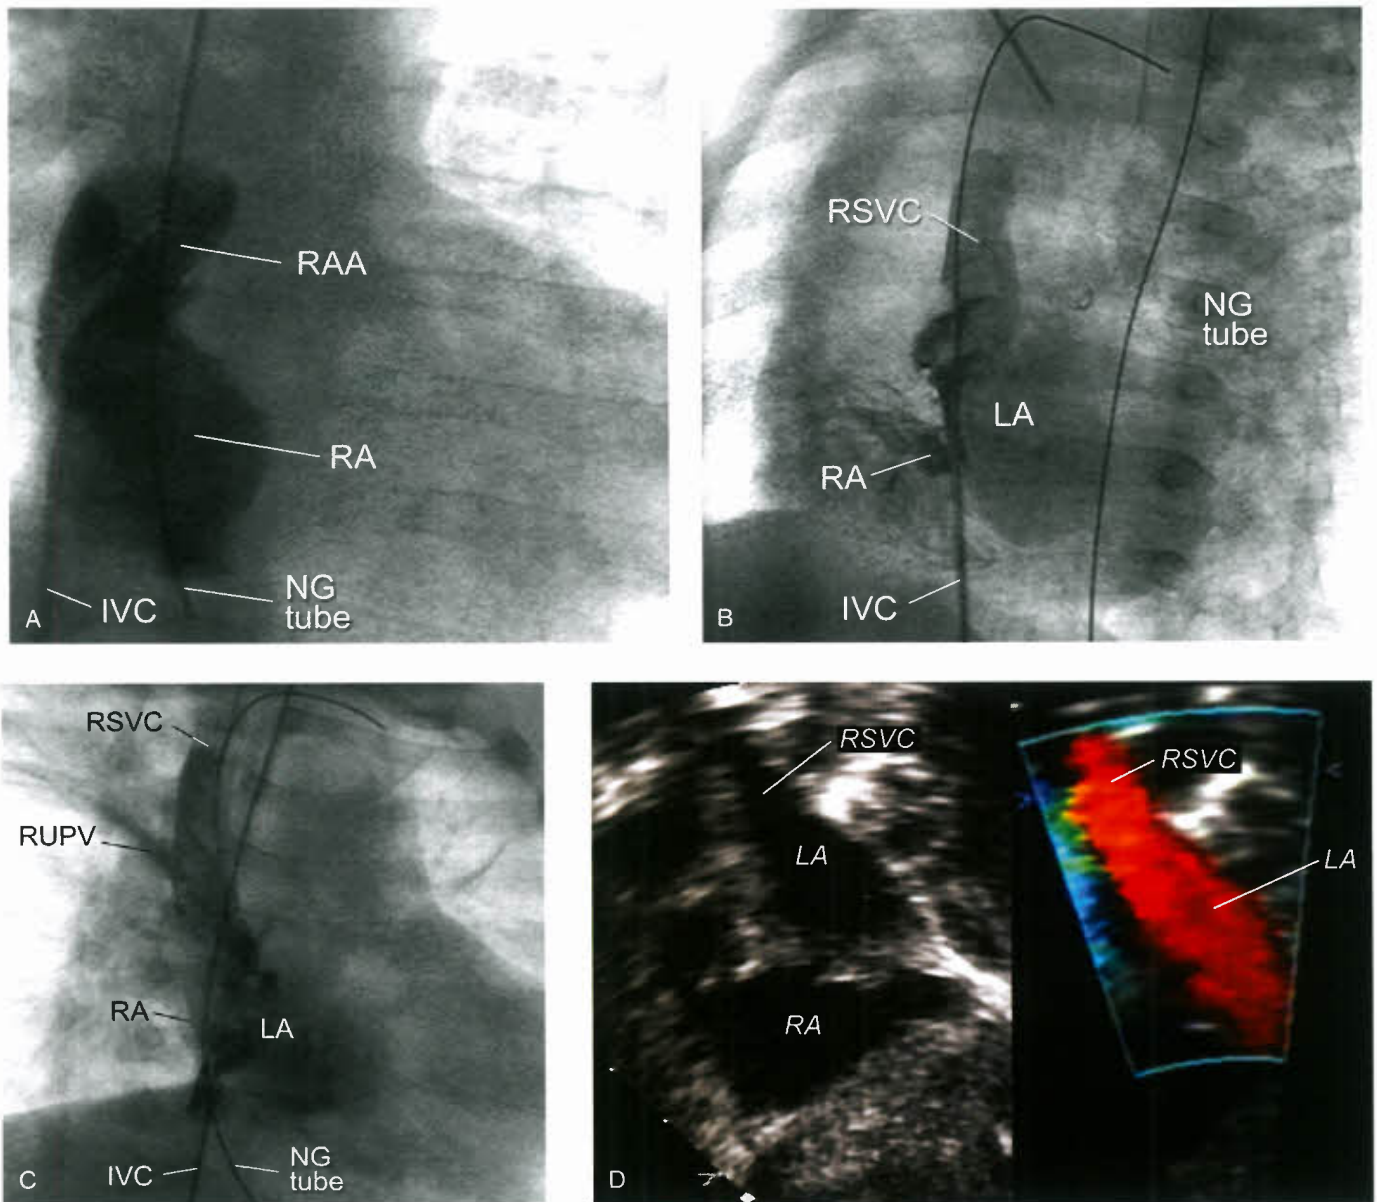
Drainage of right superior vena cava (RSVC) to left atrium (LA). A: Right atrial angiogram showing catheter course from the inferior vena cava (IVC) to the right atrium (RA). The contrast fills the RA and right atrial appendage (RAA) but not the superior vena cava. B: The catheter crosses the foramen ovale to the left atrium (LA) and is advanced into the RSVC. The RSVC-to-LA drainage is seen with contrast entering the RA through the foramen ovale. C: Drainage of the right upper pulmonary vein (RUPV) into the RSVC is seen on a later frame. D: Echocardiogram from the subcostal short-axis view showing the RSVC-to-LA drainage. NG, nasogastric.
